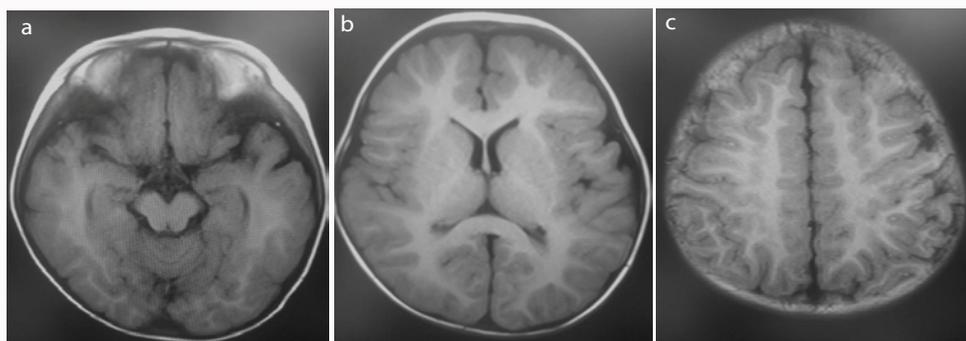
(a-c): The Magnetic Resonance Imaging (MRI) of the patient at May 5, 2015: There is no obvious abnormality without cortical or white matter abnormalities.
